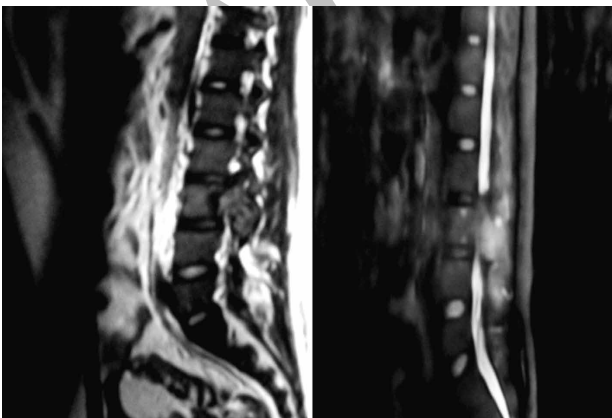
Magnetic resonance imaging demonstrated bone infiltration of that vertebra with large paravertebral and intraspinal soft tissue masses and neural compression.
